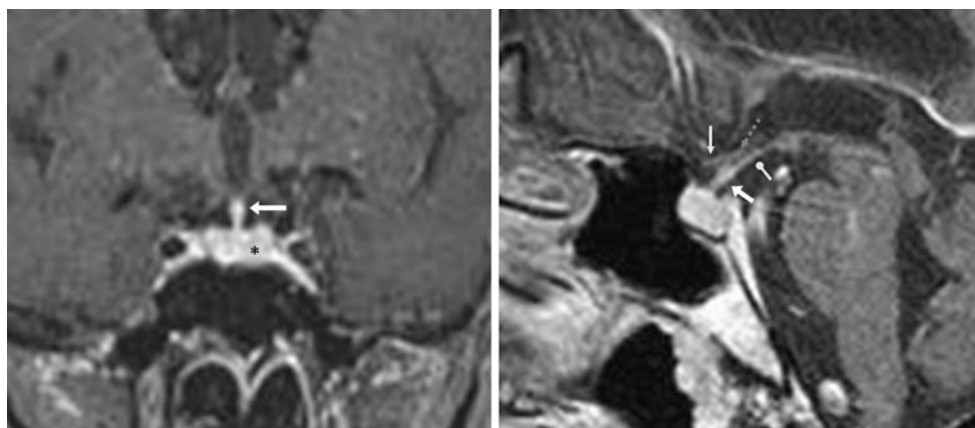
An 18-year-old female patient with 1.5 T MRI sagittal pre- (*left*) and postcontrast (*right*) T1WIs. Note normal enhancement of the infundibulum (*arrows*) relative to the nonenhancing optic chiasm (*thin arrows*). Also, note the enhancement of the median eminence of the hypothalamus (*dashed arrows*) and of the tuber cinereum (*circle tip arrows*)
